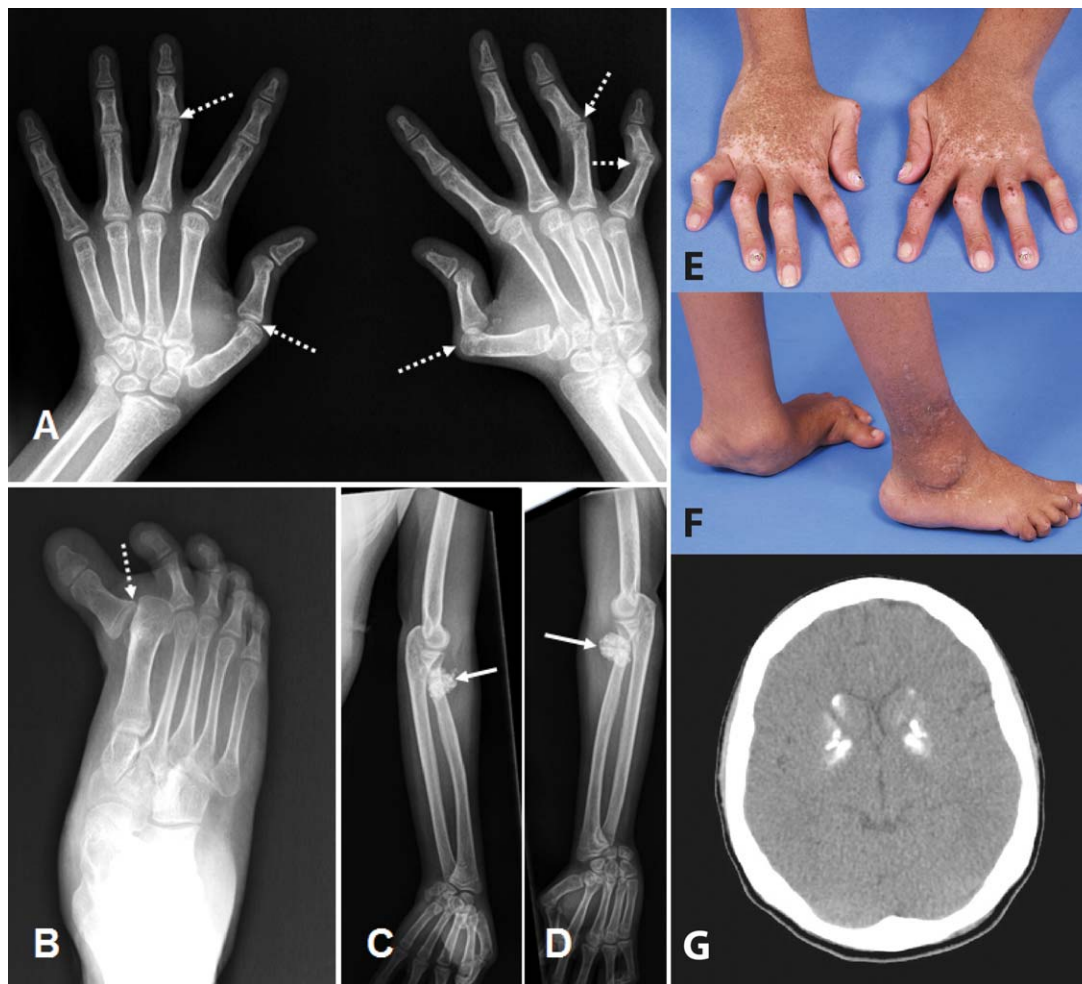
Radiologic and clinical features of patient 1 of family 1938. A–D, Radiographs of the hands (A), right foot (B), and upper limbs (C and D) at age 18 years, demonstrating subluxations (broken arrows), with well-preserved joint spaces and articular surfaces, and dense calcifications of tendon insertions at the elbows (solid arrows), which were not palpable. E and F, Photographs of the hands (E) and feet (F) at age 18 years, demonstrating camptodactyly, subluxation, and plantar collapse. Note the pigmentary abnormalities on the hands. G, Computed tomography image of the brain at age 18 years, demonstrating dense calcification of the basal ganglia (in the absence of any neurologic signs or symptoms).
